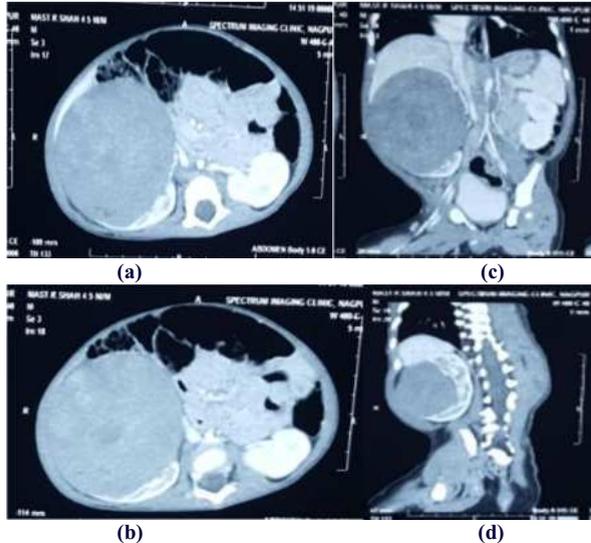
(a,b,c,d) CT scan of 4month old patient showing a large well defined solid hypodense lesion arising from anterior aspect of kidney extending from superior to inferior pole.
